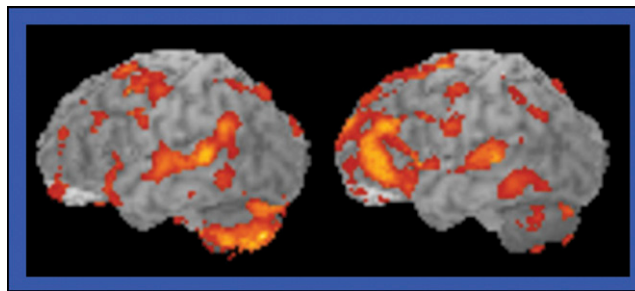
$^{99\text{m}}\text{Tc}$ -ECD SPECT in a person with a history of mild traumatic brain injury (right) showed less neuronal activation and fewer neurons than in a control subject (left).
